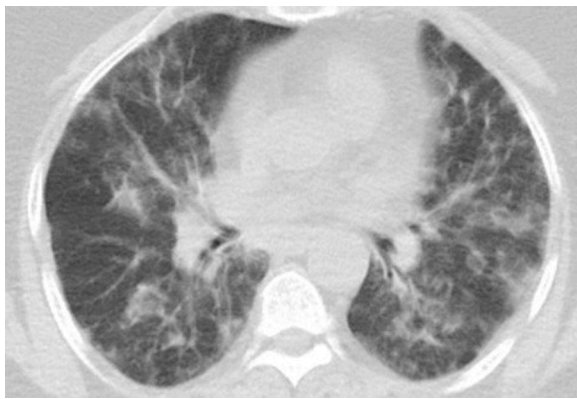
Pulmonary infiltrates detected on computerized tomography (CT) in our patient.
